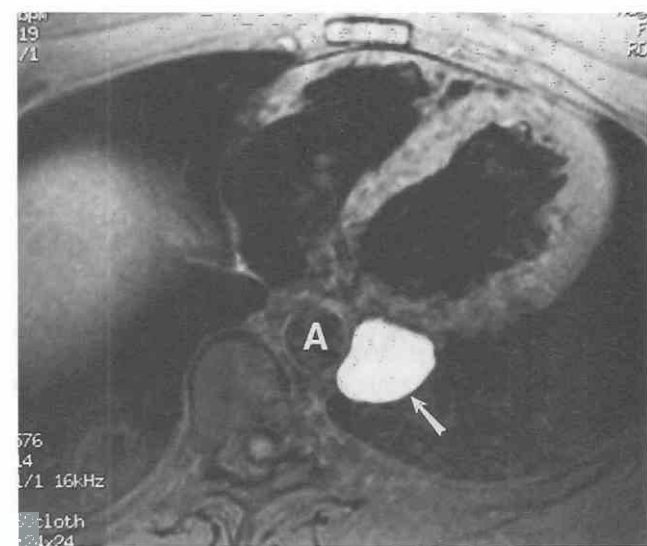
Esophageal duplication cyst. Axial T1-weighted MR image shows a well-circumscribed mass (arrow) with high signal intensity adjacent to the descending aorta (A). The MRI appearance, which is atypical for a simple cyst, is caused by proteinaceous fluid within the cyst.
